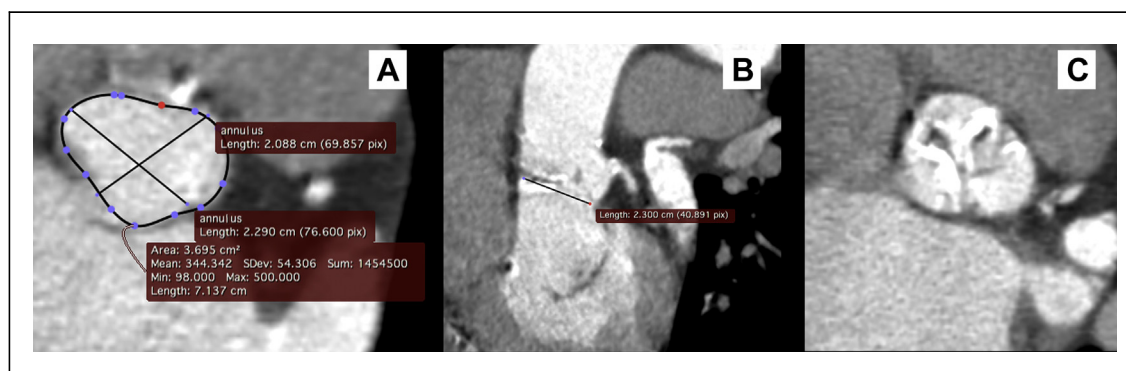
CT Scan Aortic Valve and Root Measurements
